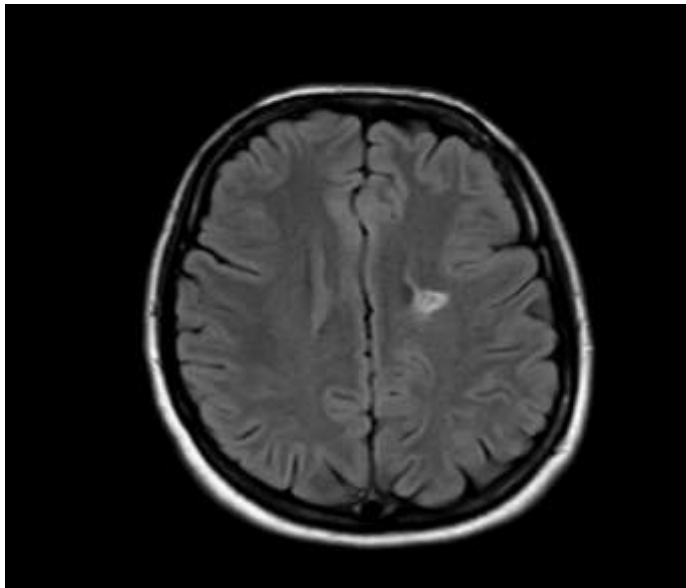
Axial MRI brain and orbit with contrast FLAIR-long TR image for patient number 45 shows old liquefied insult in the left corona radiata.
